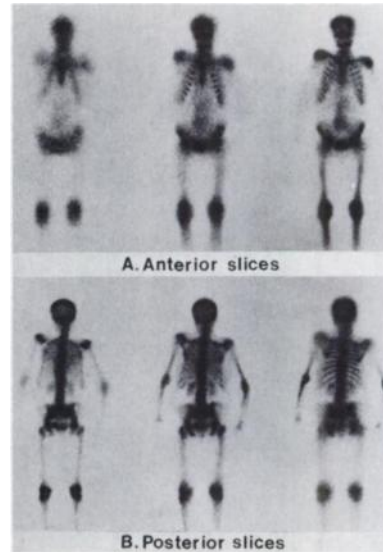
Tomographic scintigrams* obtained with Tc-99m MDP. These blurred tomographic cuts show increased bony activity throughout skeleton. Kidneys are well visualized.
